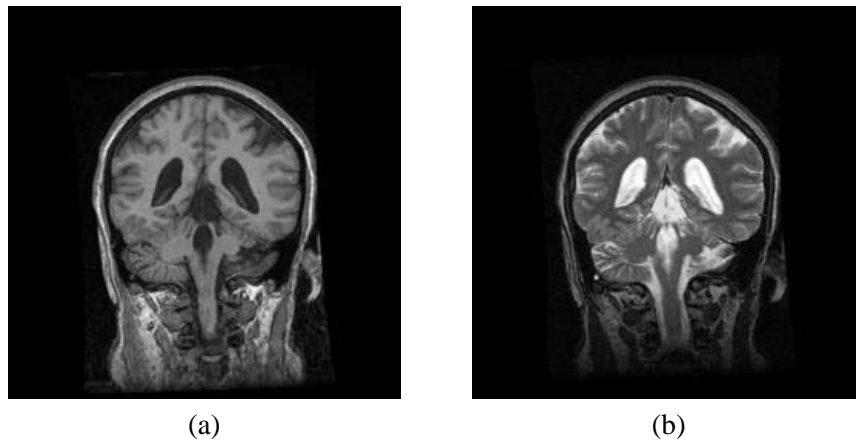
a) T1-weighted coronal slice. b) T2-weighted coronal slice corresponding to the T1-weighted slice.
